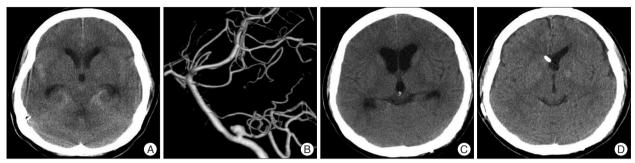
Surgery case 2. A 86-year-old female presents with subarachnoid hemorrhage due to a ruptured posterior inferior cerebellar artery (PICA) aneurysm of the anterior-medullary segment. A : Preoperative CT shows the hemorrhages in the pre-pontine and basal cistern, and in the fourth ventricle. B : Preoperative 3D-angiogram reveals a wide-necked PICA aneurysm with daughter sac in the anterior-medullary segment. C : Three-week follow-up CT shows obstructive hydrocephalus. D : One-year follow-up CT demonstrates decrease of the ventricle size after the ventriculo-peritoneal shunt.
